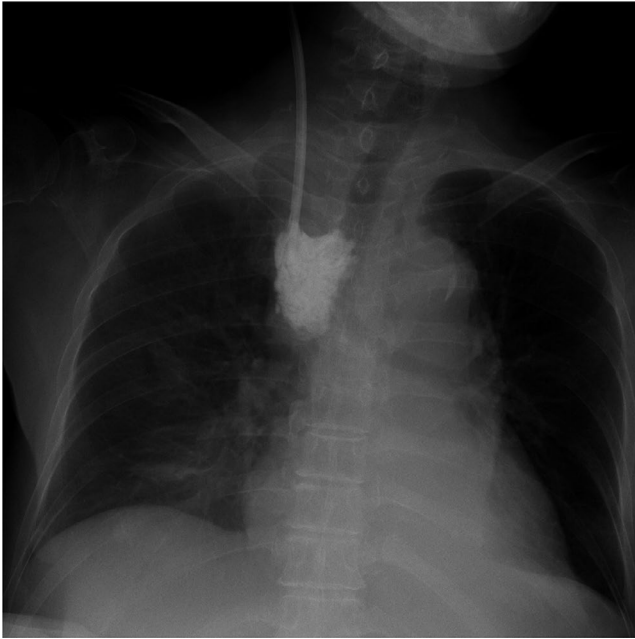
Chest X-ray after the injection of a contrast agent in the blood return line of the double-lumen catheter. Contrast agent is visible in the mediastinum
